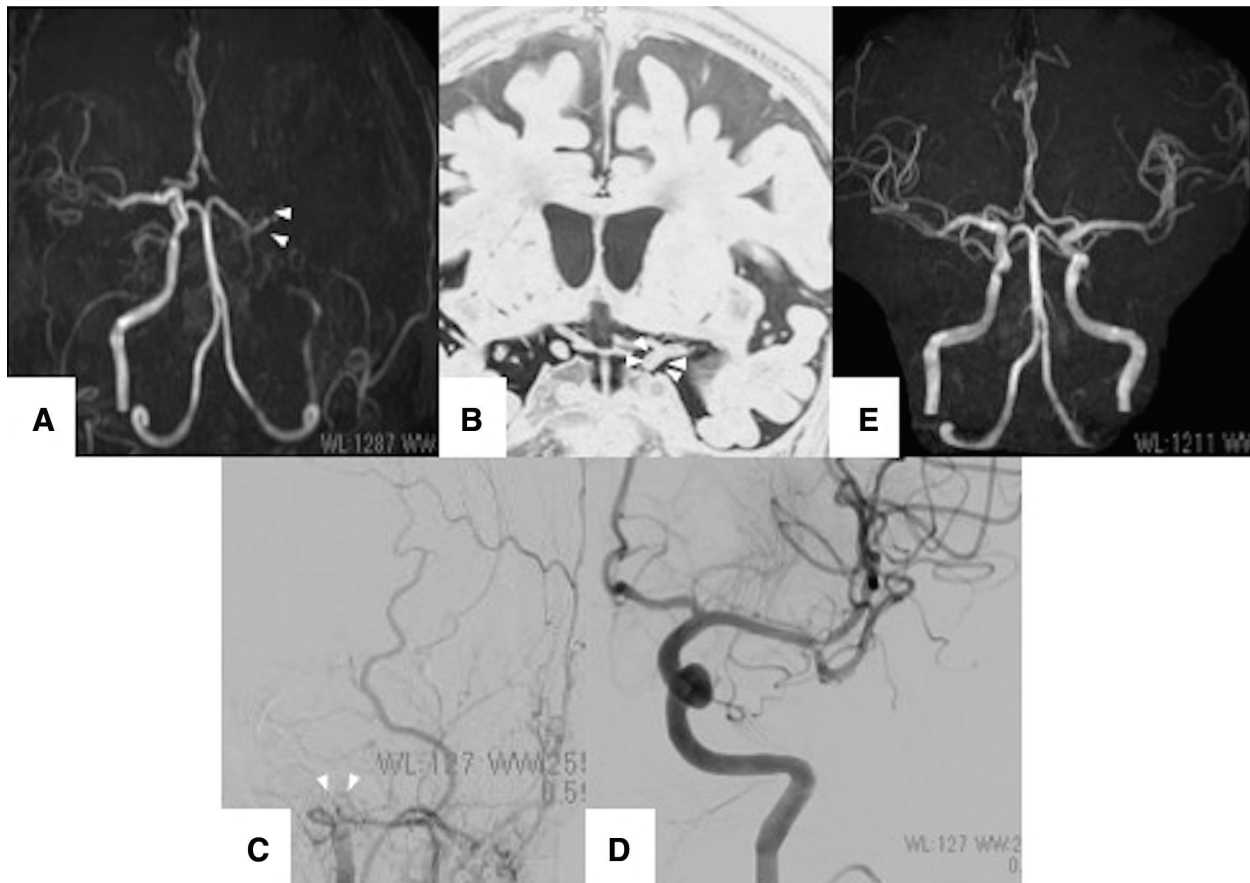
An 89-year-old-man with consciousness disturbance and right hemiparesis. (A) MRA on arrival shows left ICA occlusion. The ICA can be followed until C1. (B) The ICA bifurcation was visualized by MAS-MRI. (C) Left ICA angiography shows ICA occlusion. (D) Left
